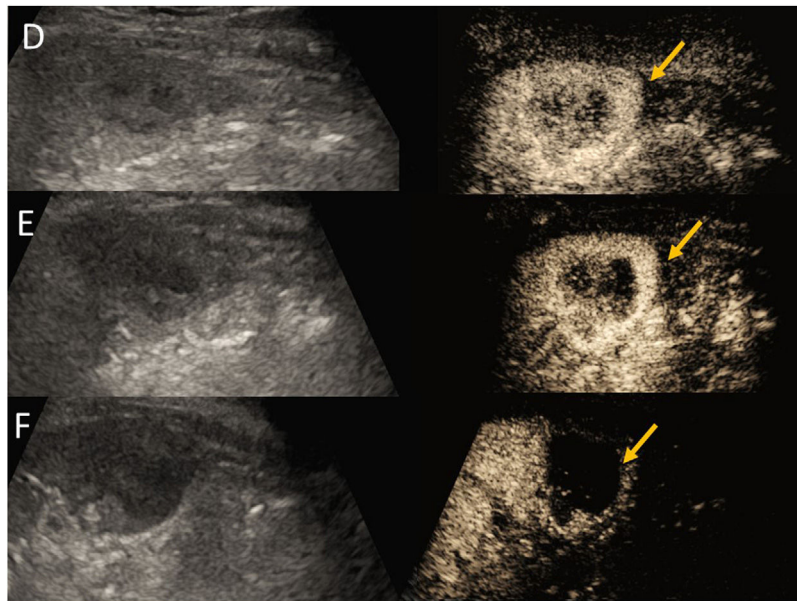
Same patient as Fig. 11. History of operated-on ovarian serous carcinoma under follow-up. Patient has a pacemaker, so magnetic resonance imaging contraindicated. (D–F) Contrast-enhanced ultrasound at 16 seconds (D), 40 seconds (E) and 3 min (F). Heterogeneous enhancement of the lesion with rapid and continuous washout identified in the late phases (yellow arrows), suggestive of a malignant lesion; in this case metastasis was suggested as a first option.
